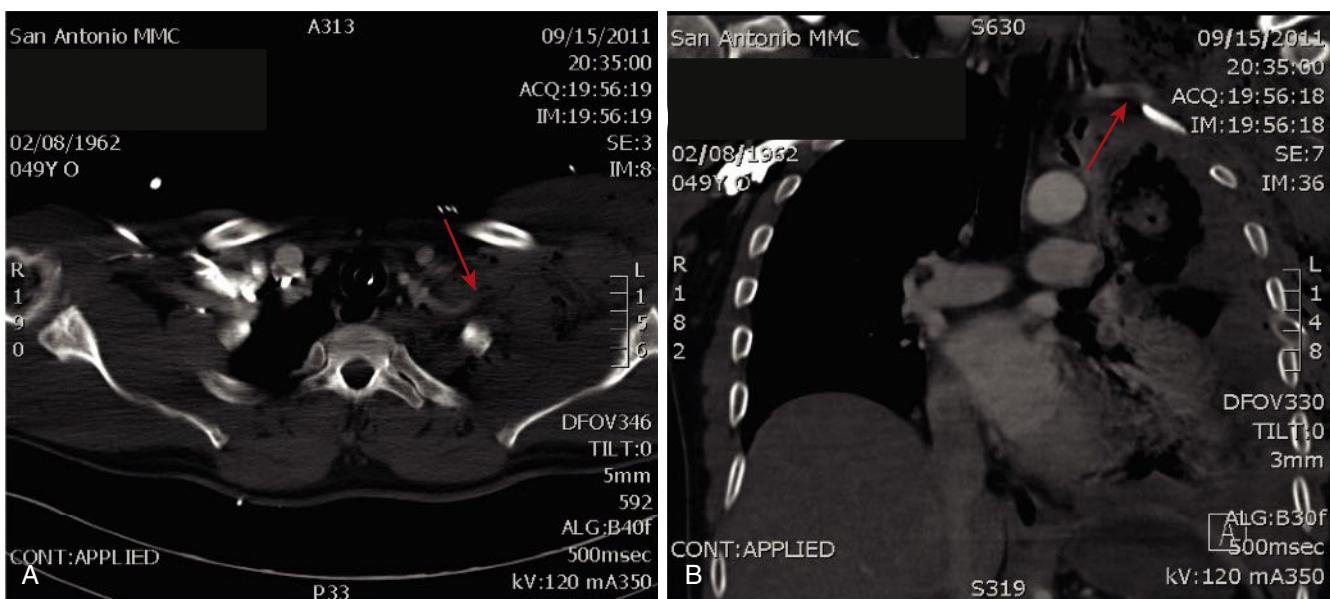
Computed tomographic angiography images from a patient sustaining a gunshot wound to the left shoulder with a pulseless left upper extremity. Note abrupt truncation of the left subclavian artery as it enters a large hematoma (A, arrow). Coronal reconstruction images reveal occlusion with intraluminal filling defect at the thoracic outlet (B, arrow).
